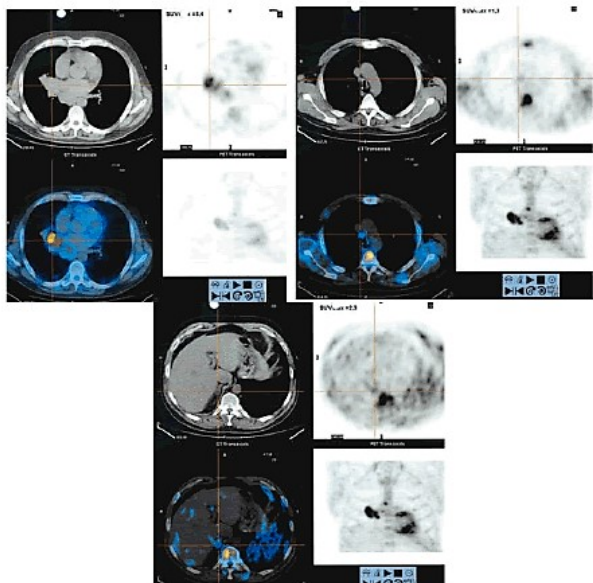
Right hilar mass (SUVmax 8.4), right hilar nodes (SUVmax 1.3), subcarinal nodes. Right adrenal nodule (SUVmax 2.3).
